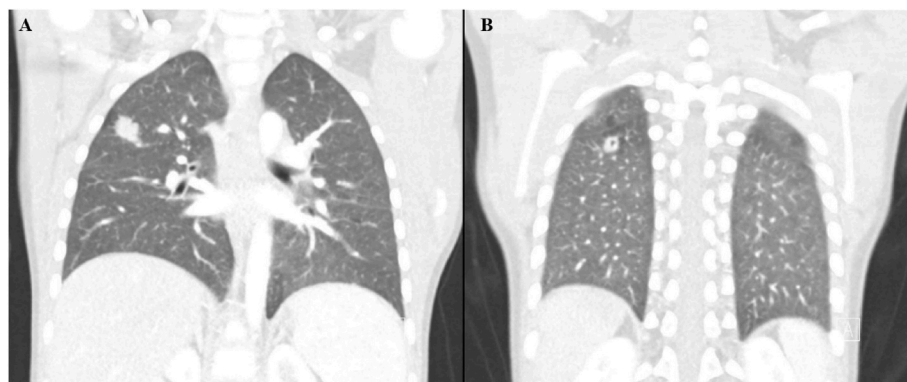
Computed tomography of the chest with contrast of patient with enlarging pulmonary nodules. A) Pulmonary nodule (1.3 cm x 1.2 cm x 1.3 cm) in the posterior segment of right upper lobe nodule. B) Pulmonary nodule (1.1 cm x 0.9 cm x 1.0 cm) in the superior segment of the right lower lobe with a small focus of gas seen within it.
